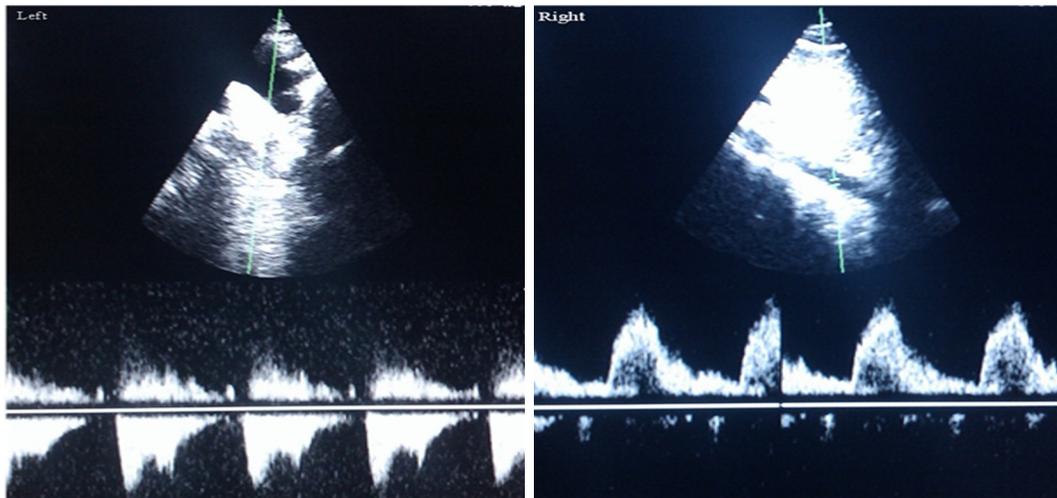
Continuous wave Doppler echocardiography of descending aorta shows no significant gradient (left). Pulsed wave Doppler echocardiography of abdominal aorta shows continuous flow with low velocity diastolic tail suggestive of abdominal coarctation of aorta (right).
